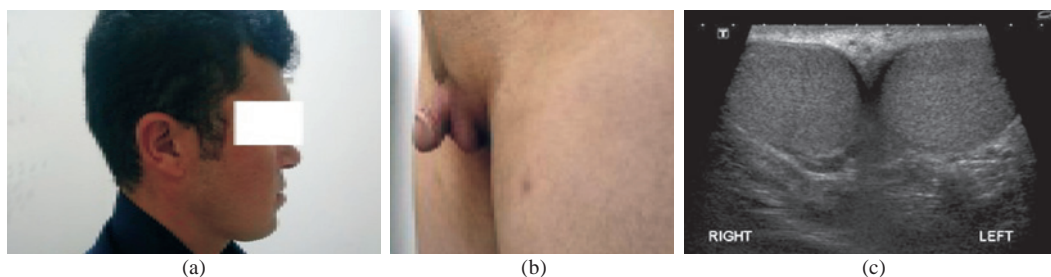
(a–c) Sample *SRY* (+) patients with 45,X/46,XY and no Y chromosome microdeletions and testes on scrotal ultrasound
